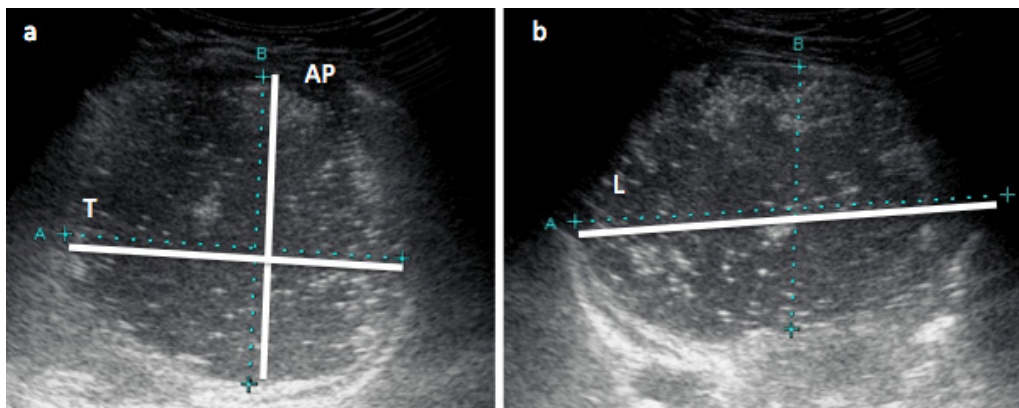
Measurements of infant's stomach with ultrasound. Ultrasound images of infant's stomach: (a) transverse view with anterior-posterior (AP) and transverse (T) diameter measurements; (b) longitudinal view with longitudinal (L) diameter (maximum length) measurement. Stomach volume (mL) = longitudinal diameter (mm) \times anterior-posterior diameter (mm) \times transverse diameter (mm) \times 0.52.
